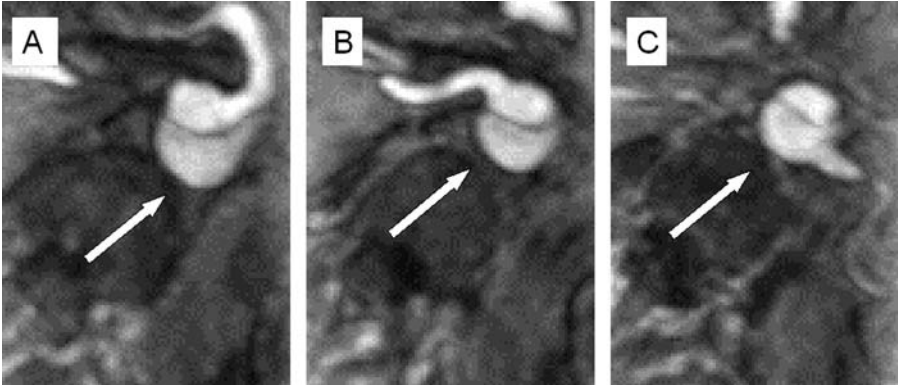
MRI images of the main abdominal aortic branches in a patient with type B dissection. White arrows: false lumen. A: Celiac trunc, originating from the true lumen. B: Right renal artery, originating from the true lumen. C: Left renal artery, originating from the false lumen.
